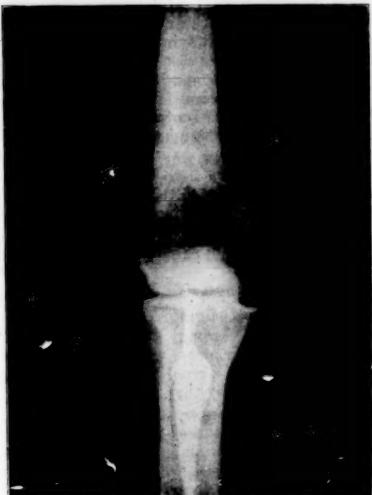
Acute osteomyelitis without X-ray evidence of bone changes.
